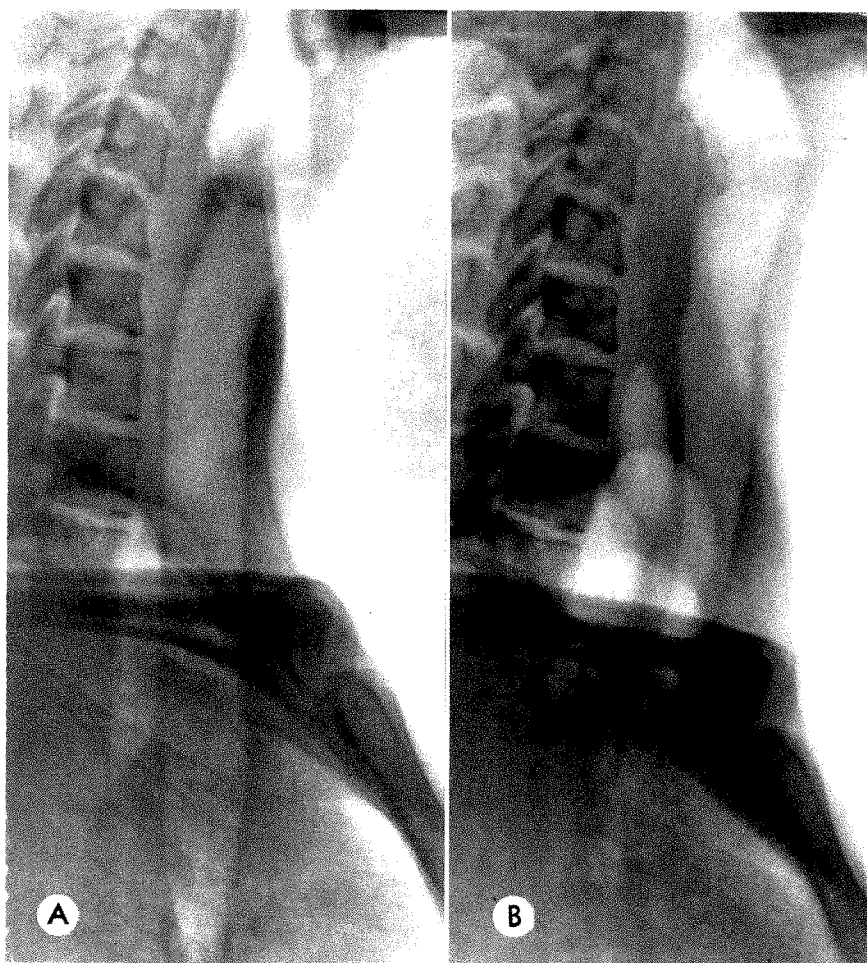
(A) Roentgenogram of the trachea of a normal subject during respiratory arrest. (B) The cervical and intrathoracic parts of the trachea are narrowed and the cervical part is displaced in the ventral direction during "voluntary wheezing expiration."
